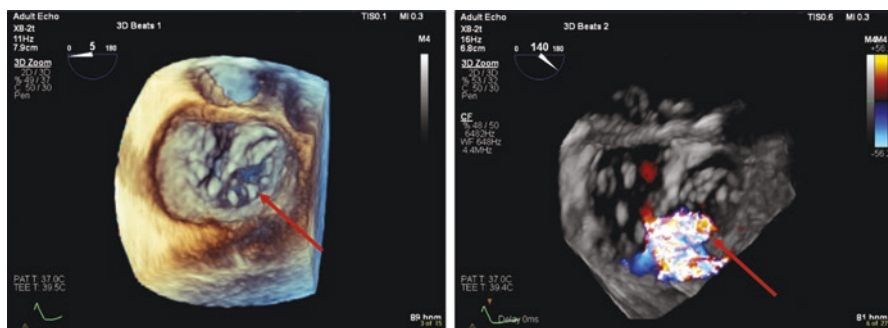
Three-dimensional echocardiography datasets demonstrating retraction of the posterior mitral valve leaflet at the level of the medial scallop of the mural (posterior) leaflet P3 in patient with prolapse of the aortic (anterior) mitral valve leaflet central scallop A2 shown by red arrow in the left-sided image, accentuating the mitral regurgitation on the medial aspect (shown by the red arrow in the right-sided image)
